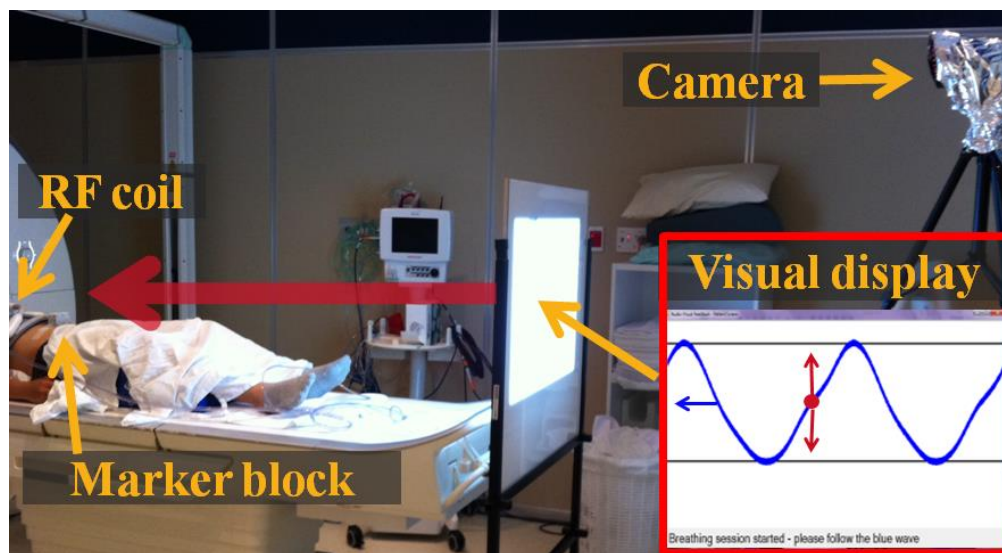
AV biofeedback system for respiratory-gated 3D MR imaging in a 3T Skyra Siemens MRI.
